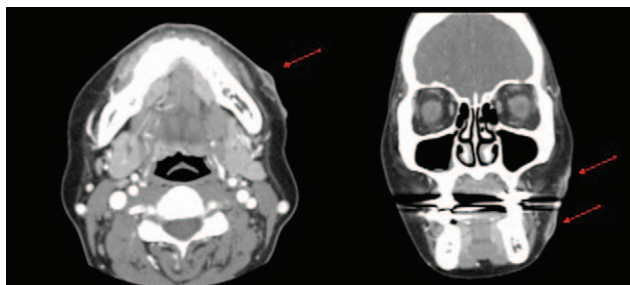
Computed tomography scan displays multiple small nodular lesions in the subcutaneous layer of both cheeks of the patient (red arrow).
